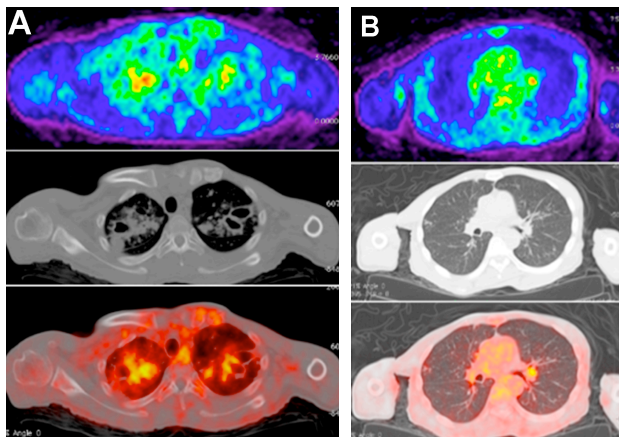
A 44 yr old man with HIV and TB demonstrated increased ^{68}Ga -citrate accumulation in the apices of both lungs (A) which corresponded to the areas of cavitations noted on CT together with (B) mediastinal lymph node involvement indicative of active tuberculosis. These transverse mages were acquired on a Siemens Biograph 40 PET/CT scanner at 60 minutes post-injection of 185 MBq of ^{68}Ga -citrate.
